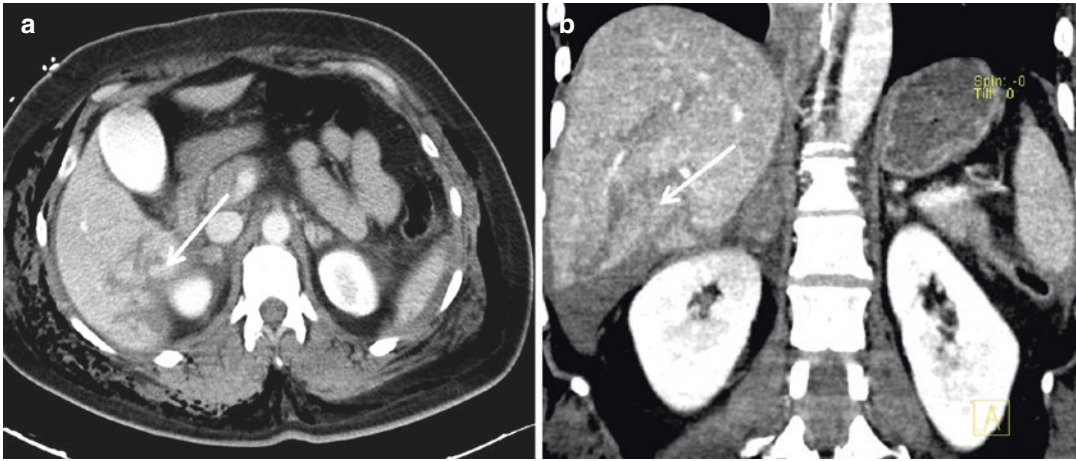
Hepatic trauma, grade III: (a) Axial CT scan and (b) coronal reconstruction show multiple lacerations with thickness >3 cm
